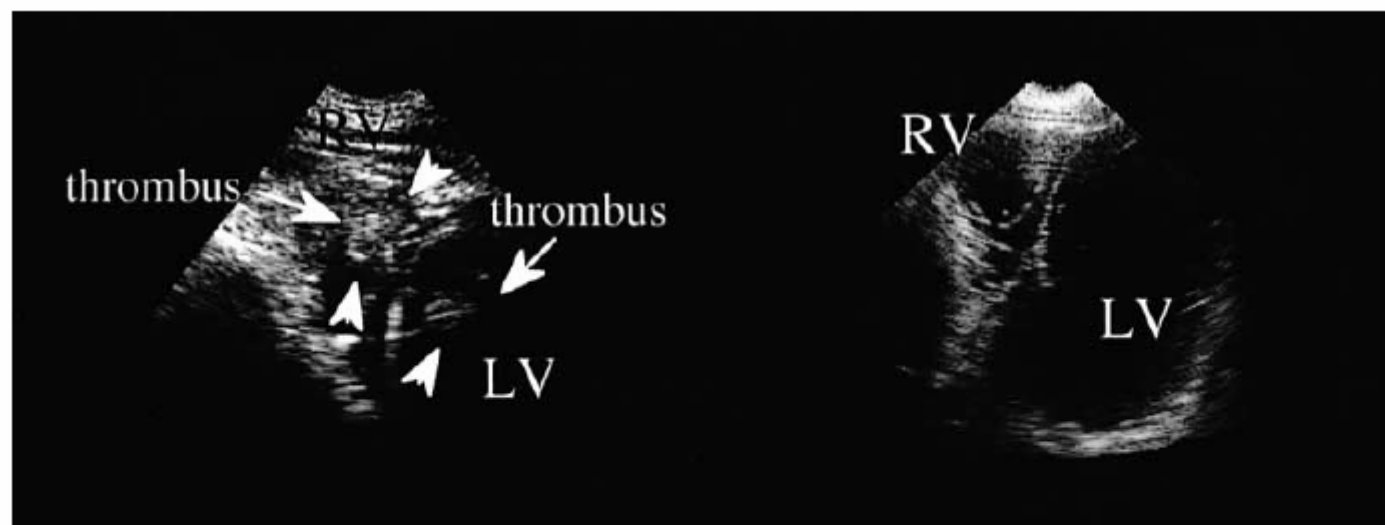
Echocardiography showing apical thrombi, which measured 10mm in diameter at presentation, within both ventricles (A, left), but which had disappeared 4 days after intravenous heparin therapy (B, right). LV, left ventricle; RV, right ventricle.
